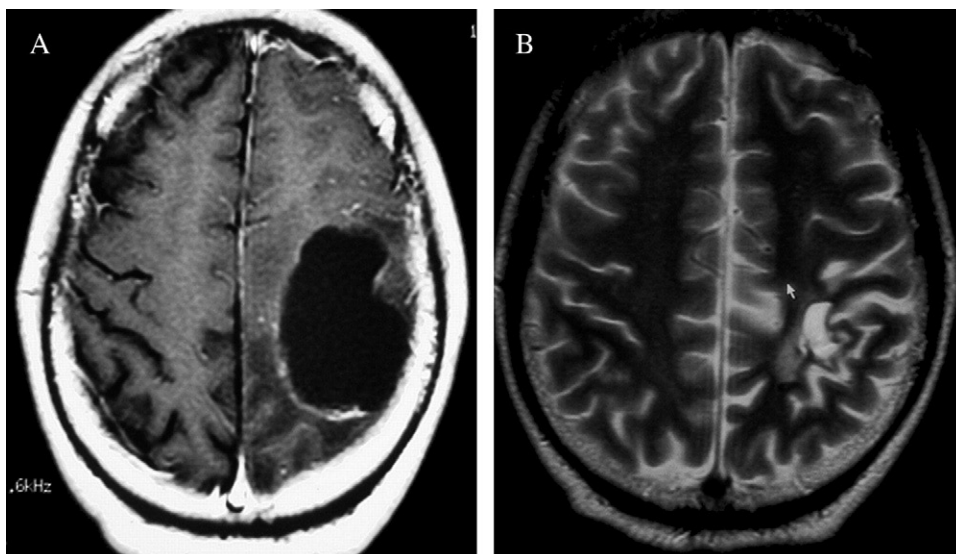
Delayed cyst formation after radiosurgery of left parietal AVM (case 6): T₁-weighted MRI before surgical treatment (A) and T₂-weighted MRI 2 years thereafter (B).
